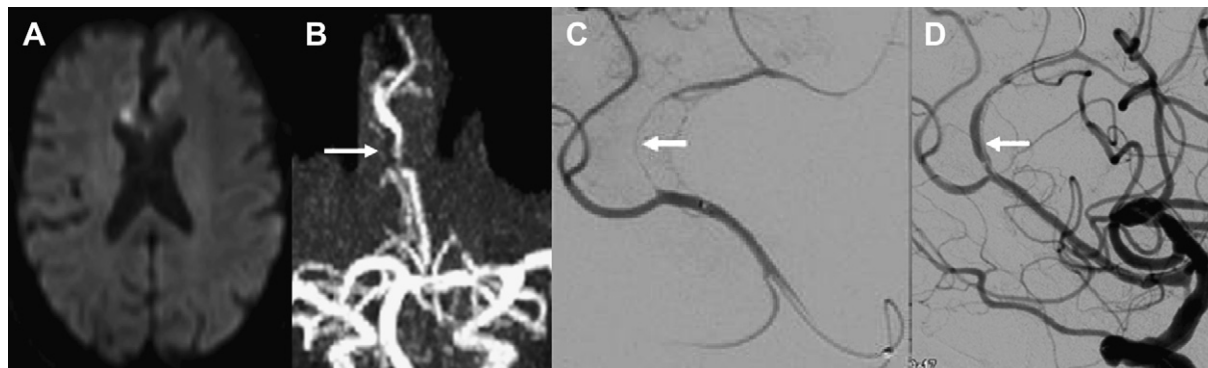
Diffusion-weighted MRI showing only positive small and focal hyperintense lesion at right anterior corpus callosum (A). MR angiography in anterior projection is showing critical pericallosal artery stenosis with string sign (B). Digital subtraction angiography of right anterior cerebral artery via microcatheter (C) performed 6 months after MRI showing critical stenosis of pericallosal artery starting at A2 segment bifurcation. Balloon angioplasty using 1.5- × 15-mm balloon with final result showing near complete reconstitution of pericallosal artery lumen (D).
